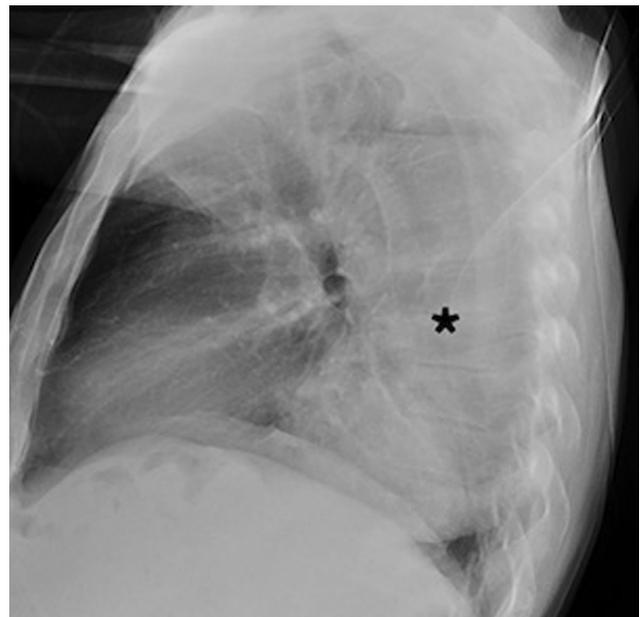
Lateral chest x-ray shows an increased density along the posterior mediastinum (asterisk), suggestive of a dilated esophagus.
